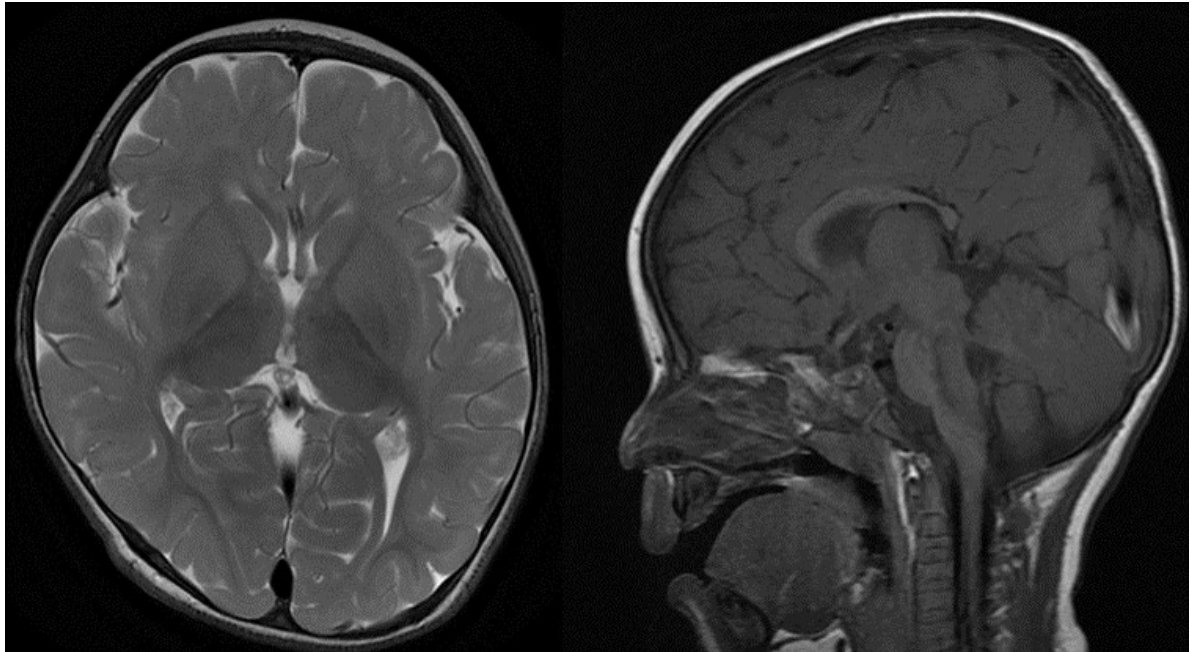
Brain MRI (T1-weighted, axial (left) and sagittal (right)). Suspected decreased white matter volumes in parietal areas, with small splenium and posterior body of corpus callosum
